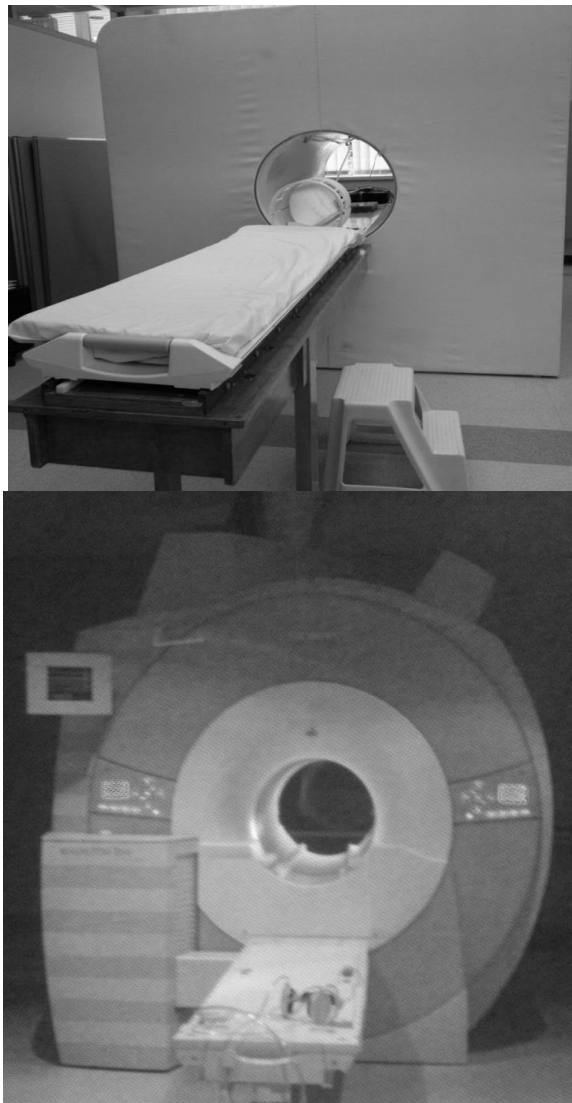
MRI and mock scanner comparison.
